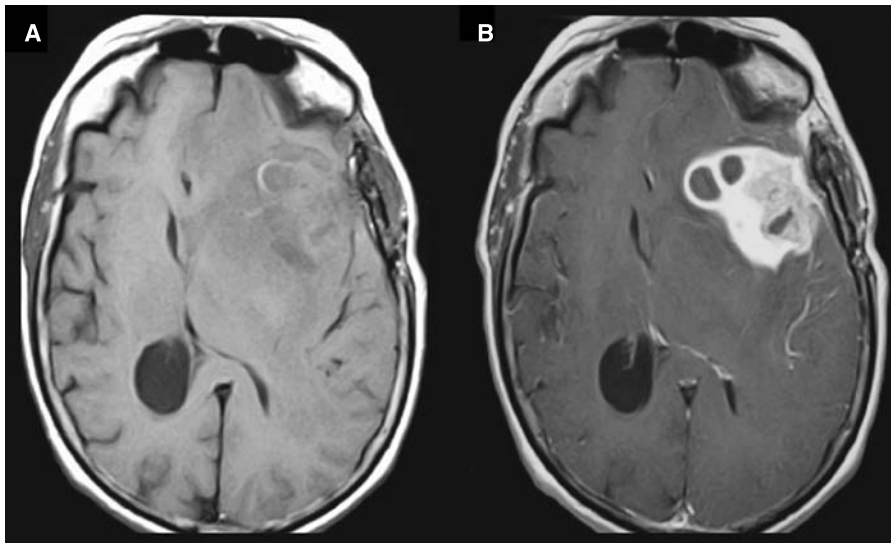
Native (A) and gadolinium-enhanced (B) T1-weighted MR tomography demonstrating a non-homogeneous contrast enhancing mass in the anterior part of the left sylvian fissure with low signal on native T1-weighted images. There is significant mass effect with midline shift, subfalcine herniation and unilateral obstructive hydrocephalus
